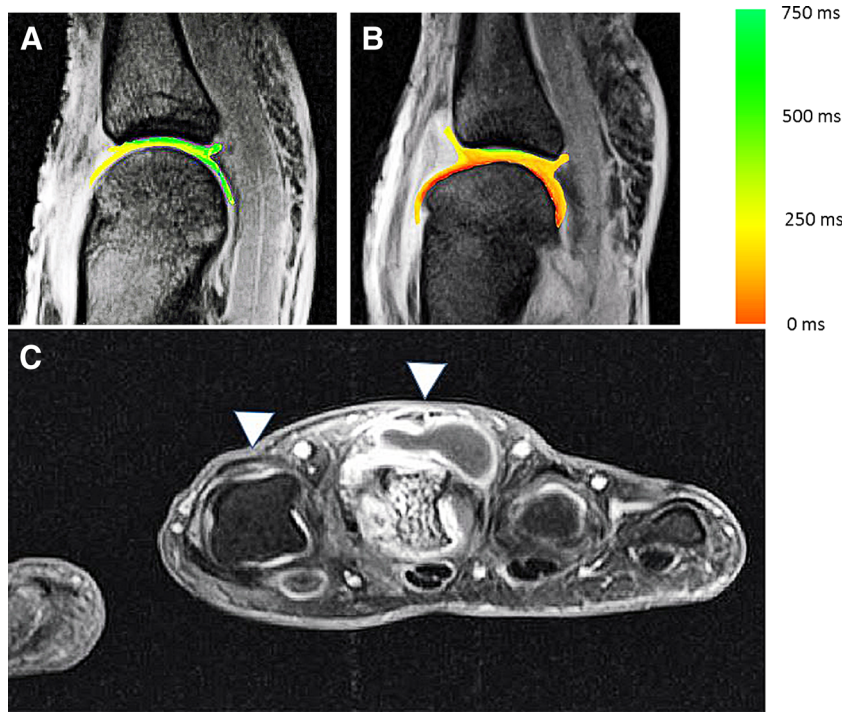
Transversal fat-suppressed T1-weighted sequence [field of view (FOV) 13×18 cm, matrix size 256×182 pixels] of a patient with RA showed identical RAMRIS synovitis sub-scores of MCP 2 and 3 (white arrows). In this condition, two radiologists decided in consensus on the joint with more severe synovitis and the joint with less severe synovitis. In this patient, MCP 3 was defined as the joint with more severe synovitis. Additionally, there is a tenosynovitis of the flexor tendon of the third finger
